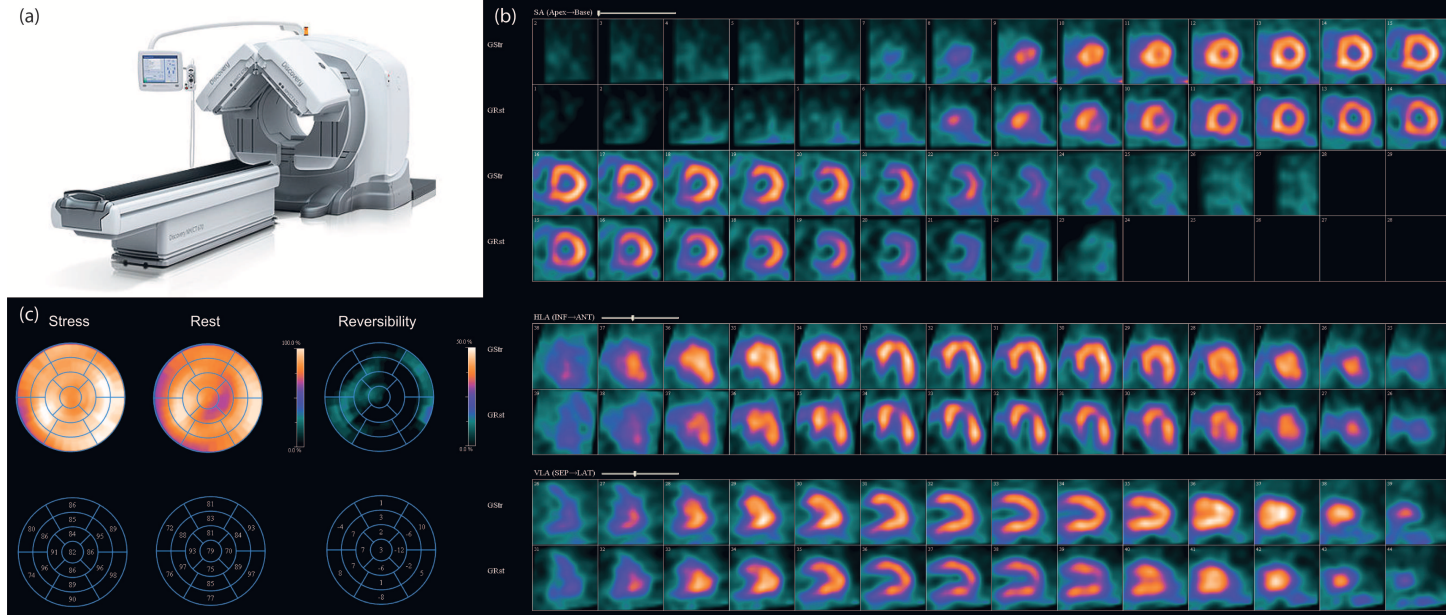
Single-Photon Emission Computed Tomography (SPECT). (a) X-ray CT scanner combined with a dual head SPECT gamma camera (Discovery NM/CT 670, GE Healthcare). (b) Example of images generated by SPECT exam. (c) Example of stress, rest and reversibility polar maps used for interpretation.
